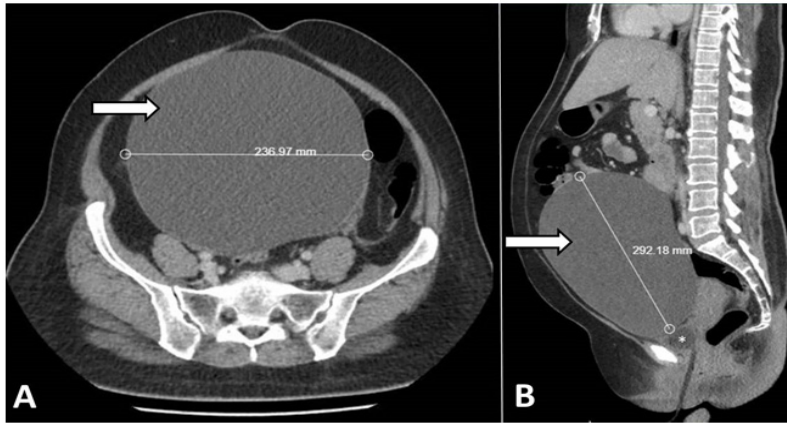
(A) Axial CT scan of abdomen showing large adnexal cyst (white arrow) with largest diameter measuring 236.97 mm (B) Sagittal CT scan of abdomen showing large adnexal cyst (white arrow) visualized separately from the bulb of foley catheter (white asterisk).
